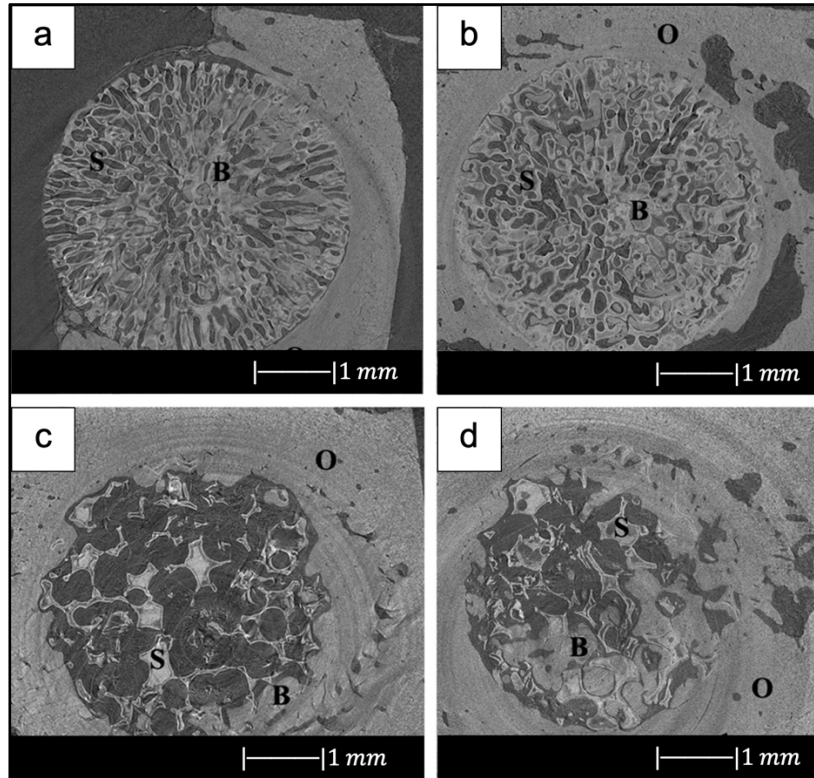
Synchrotron micro-computed x-ray tomography images of 13-93 BG oriented scaffold after implantation for (a) 12 weeks and (b) 24 weeks, and 13-93 BG trabecular scaffold after implantation for (c) 12 weeks and (d) 24 weeks. The distribution of old bone (O), new bone (B) and the bioactive glass scaffold (S) is given. Figure adapted from Liu et al. [26].
